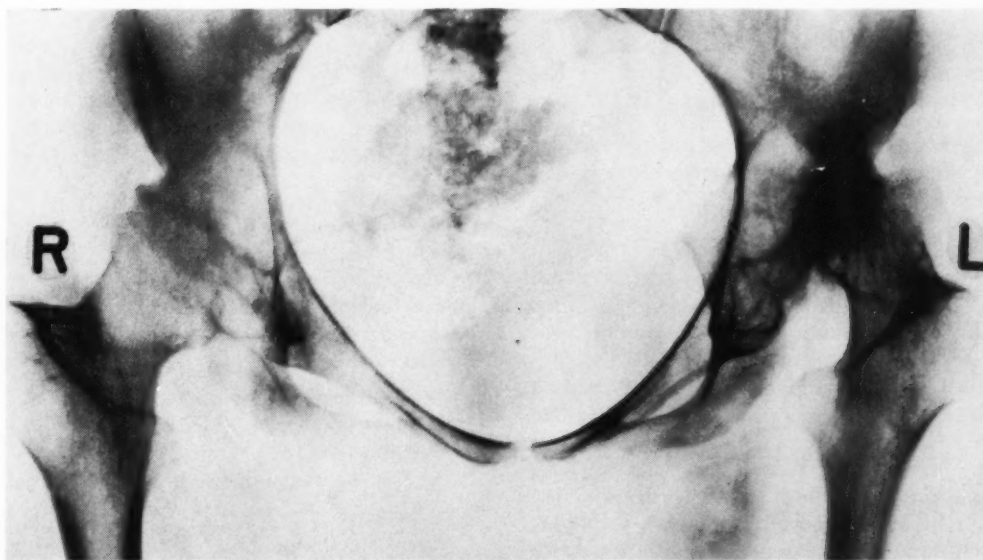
Roentgenogram of hips in Case 2, age 17 $\frac{3}{4}$ years. Note 1) almost complete subluxation of the left hip, 2) flattening of femoral heads, 3) acetabular distortion on both sides, 4) narrowing of joint space on the right, and 5) decalcification. Onset of rheumatoid arthritis had been at age three with rapid progression to involvement of all joints. At time roentgenogram was taken the patient was able to walk without crutches, there was difficulty in getting up from a sitting position, and the hips had marked flexion contractures with only a little motion remaining.
